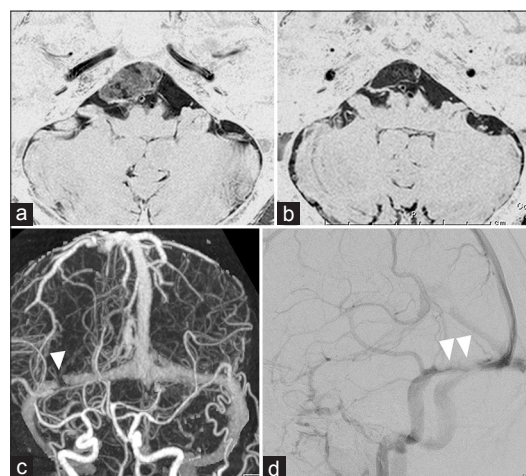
Brain tumor at the right cerebellopontine angle and temporal middle fossa of a 54-year-old female. Constructive interference in steady state magnetic resonance image shows a tumor at the right cerebellopontine angle and temporal middle fossa (a). Tumor resection via the presigmoid transpetrosal and retrosigmoid approach on magnetic resonance image constructive interference in steady state image (b). Preoperative three-dimensional enhanced computed tomography angiography (c) and digital subtraction angiography (d) images show right transverse sinus stenosis (arrowhead)
